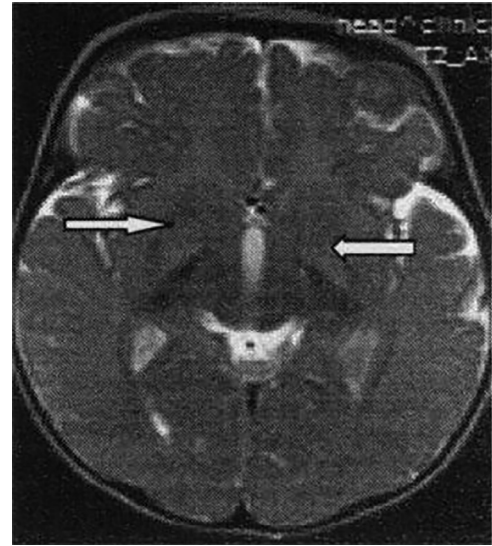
Case 1. Axial T2W magnetic resonance image showing bilateral T2 hyperintensities of the globus pallidus (arrows).
